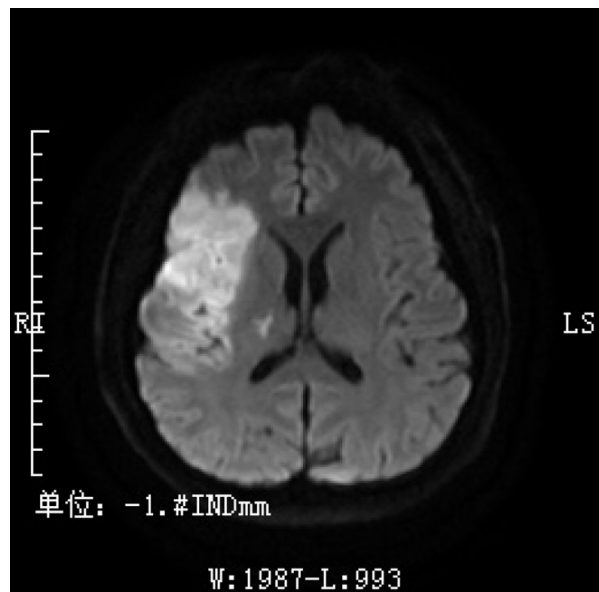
Diffusion-weighted imaging of cranial MRI 20.5 hours after intravenous thrombolysis, which showed cerebral infarction. Abbreviation: MRI, magnetic resonance imaging.
